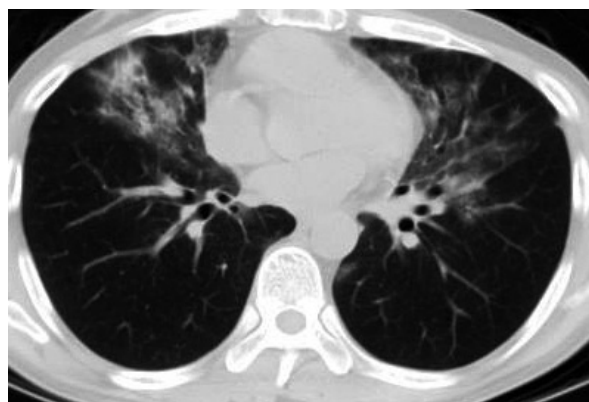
Chest computed-tomography (CT) revealed ground glass attenuation at the bilateral middle lung fields with consolidation and subpleural fibrosis
